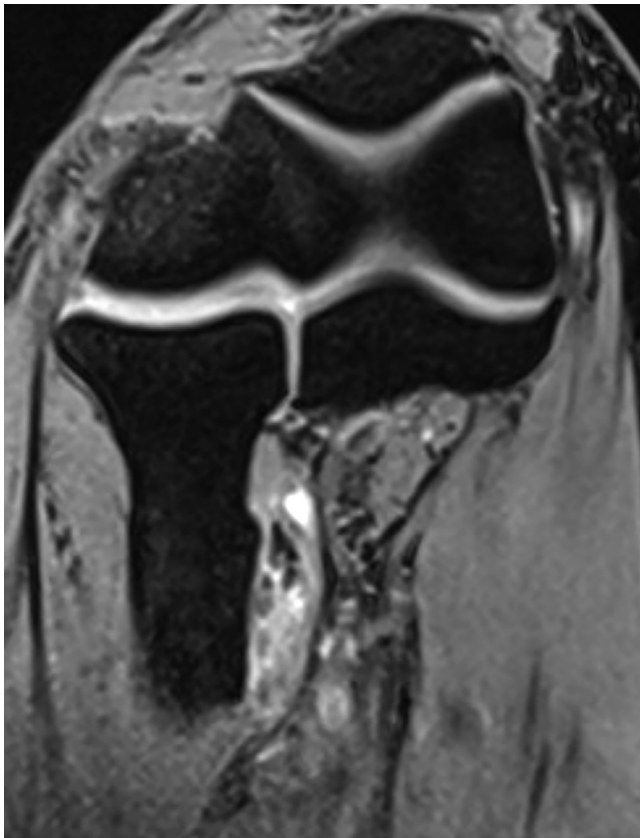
Flexion-abduction-supination magnetic resonance imaging view (3-dimensional double-echo steady-state with water excitation) showing high-grade partial tear of distal biceps tendon. Courtesy of MoRe Foundation.
